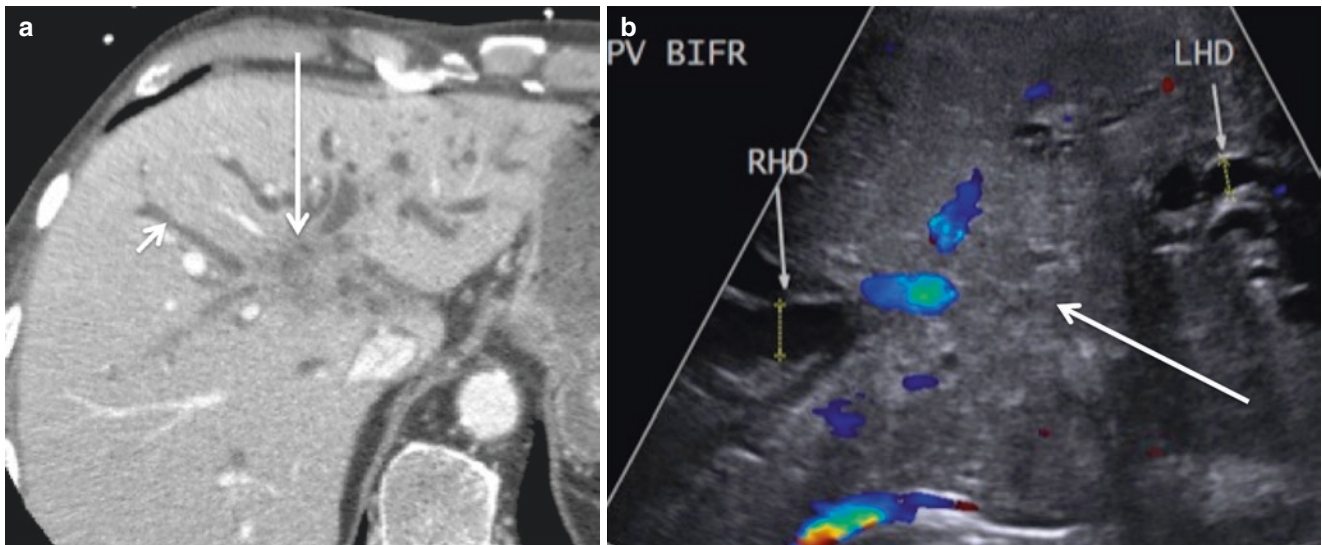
Contrast-enhanced axial CT image of the abdomen (a) and transverse sonographic image centered at the hepatic hilum in a patient presenting to the ED with jaundice and right upper quadrant pain. The CT image depicts intrahepatic biliary ductal dilation (*short arrow*) and a hypoenhancing hepatic hilar mass, typical of cholangiocarcinoma
